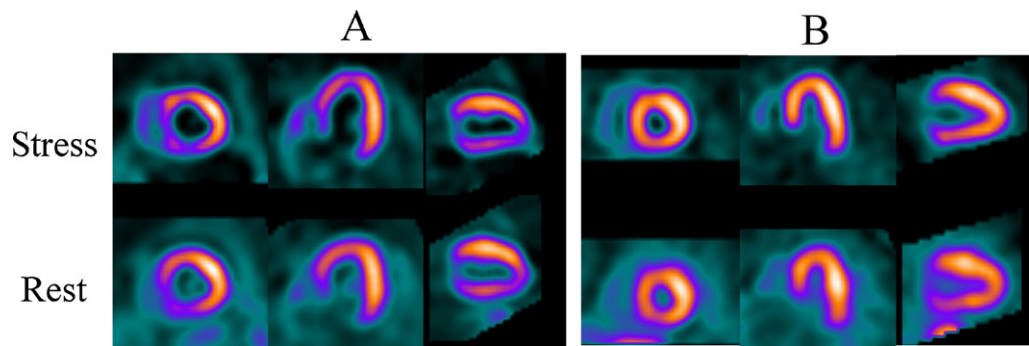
Typical stress/rest single photon emission computed tomography myocardial perfusion images in patients with cardiac death (A) and without any major cardiac events (B). (A) The image was obtained from a 77-year-old male patient having hypertension, diabetes mellitus, history of myocardial infarction, and estimated glomerular filtration rate (eGFR) = 24.8 mL/min/1.73 m², who died of cardiac events. Hypoperfusion was observed in septal, apex, and inferior segments; the summed stress score (SSS) was 19, the summed rest score (SRS) was 17, and the summed difference score was 2. (B) The image was obtained from a 79-year-old male patient having hypertension and eGFR = 33.8 mL/min/1.73 m², who did not experience any major cardiac events. It indicated normal perfusion with SSS = 0, SRS = 0, and SDS = 0.
